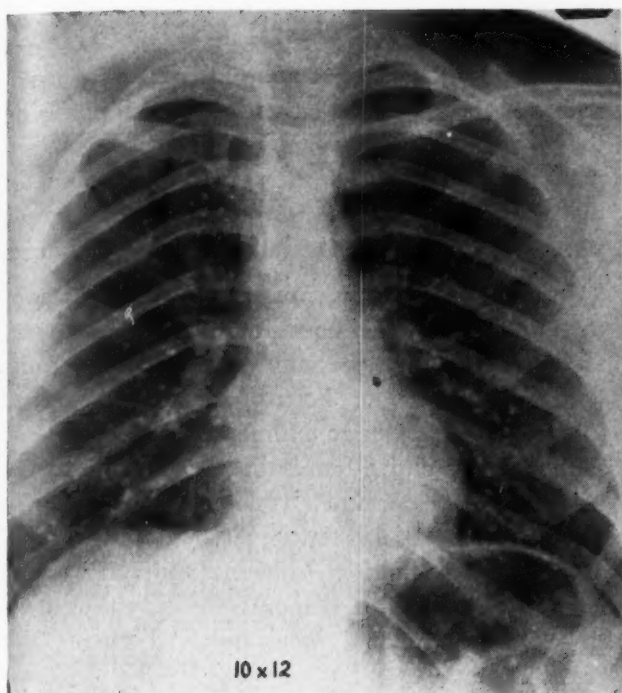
Chest x-ray of Betty Jean S. in September, 1944, showed multiple fine discrete areas of increased density in both lung fields.
